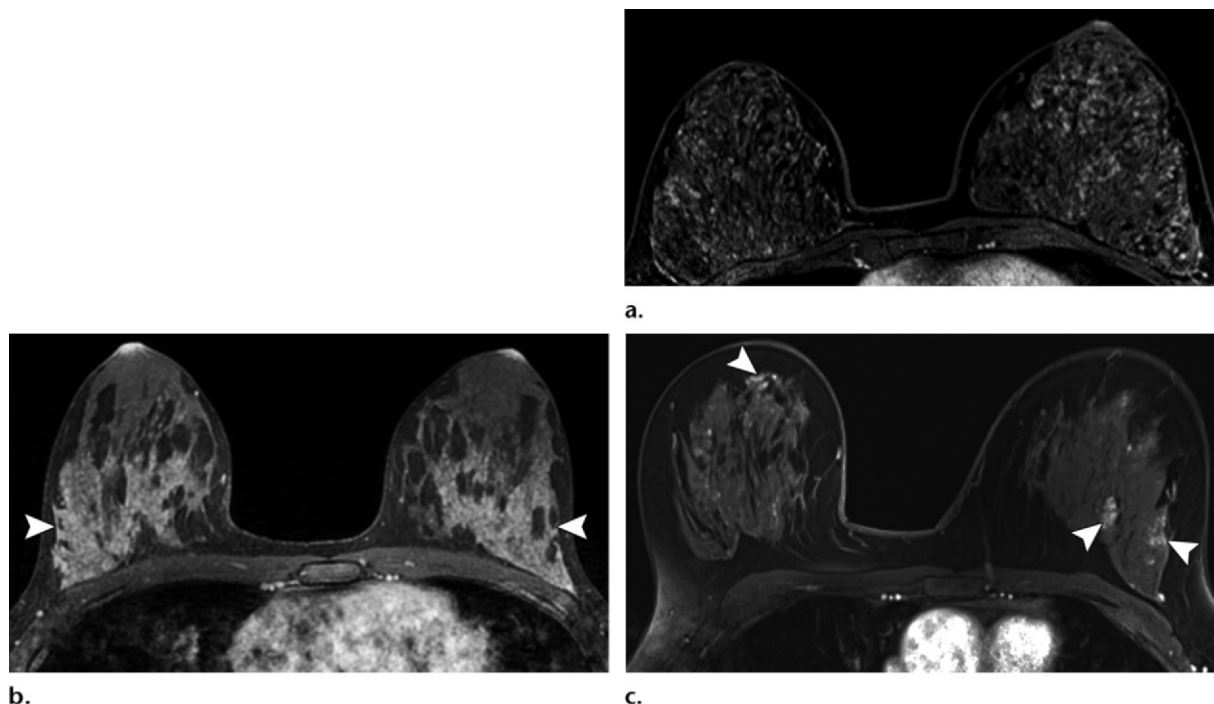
Various distribution patterns of BPE in three different women. (a) Axial contrast-enhanced T1-weighted fat-suppressed MR subtraction image shows diffuse, mild to moderate, symmetric, stippled BPE. (b) Axial contrast-enhanced T1-weighted fat-suppressed MR image shows bilateral, symmetric, moderate, regional BPE (arrowheads). (c) Axial contrast-enhanced T1-weighted fat-suppressed MR image shows multiple foci and focal areas of mild BPE (arrowheads). In the pre-BI-RADS lexicon, this finding was termed *focal and nodular areas of enhancement* (3) or *patchy and nodular BPE* (25).
